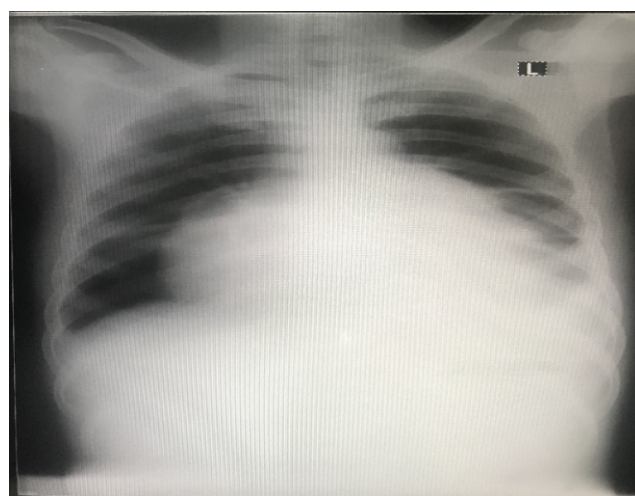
Chest x-ray of the pericardial effusion
